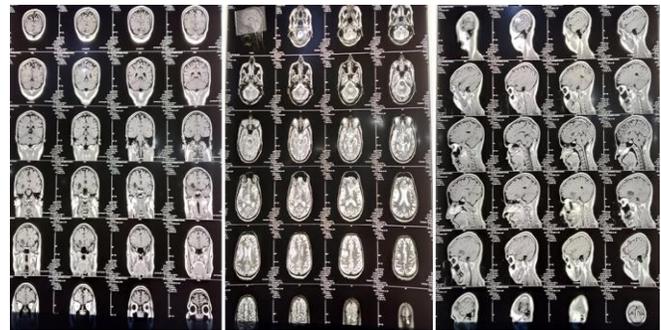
Contrast enhanced MRI brain revealing ring enhancing lesions.
